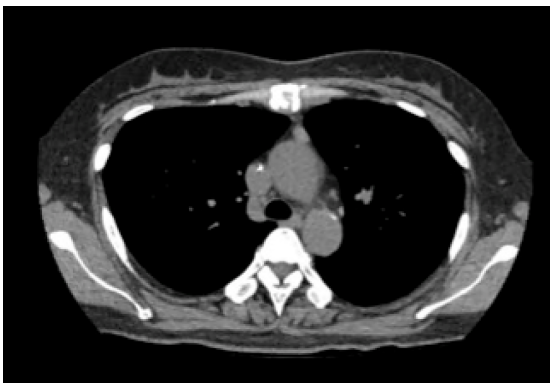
Chest computed tomography shows that the mass around the upper sternum was reduced obviously.
